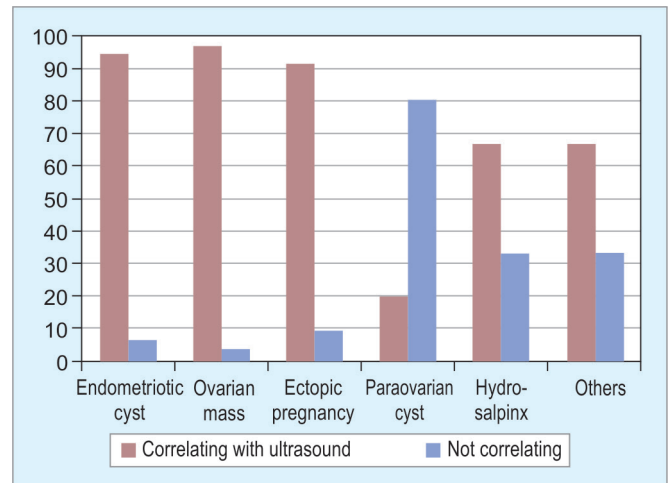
Correlation of laparoscopy findings with ultrasound
